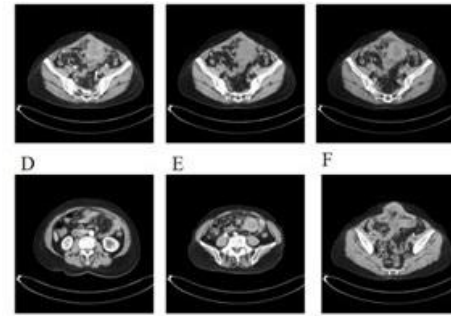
The abdominal CT. A: The red arrows point to the dilation of the small intestine in the abdominal cavity, and the gas-liquid plane is visible inside; B: The red arrows point to the local soft tissue density shadow in the pelvic intestine, and the enhanced scan shows uneven enhancement and pelvic fluid accumulation.
